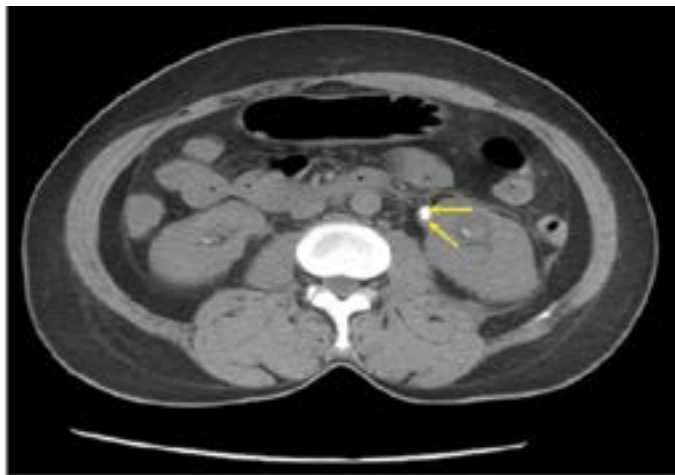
Computed tomography of abdomen shows stones in left upper ureter and right kidney.
